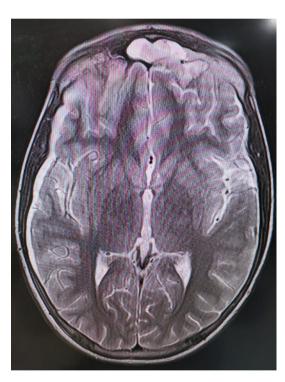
MRI brain with contrast during the follow up after 1 week
